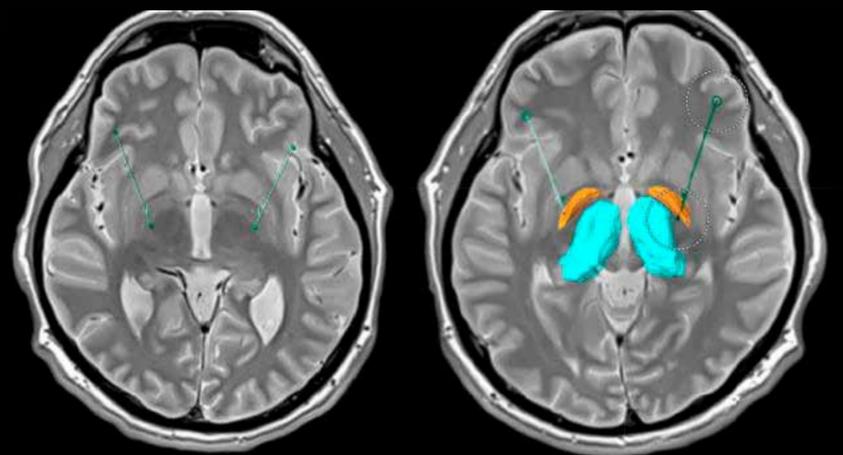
Preoperative 3T MRI T1 MPRAGE images showing the obtained target in bilateral GPi.
